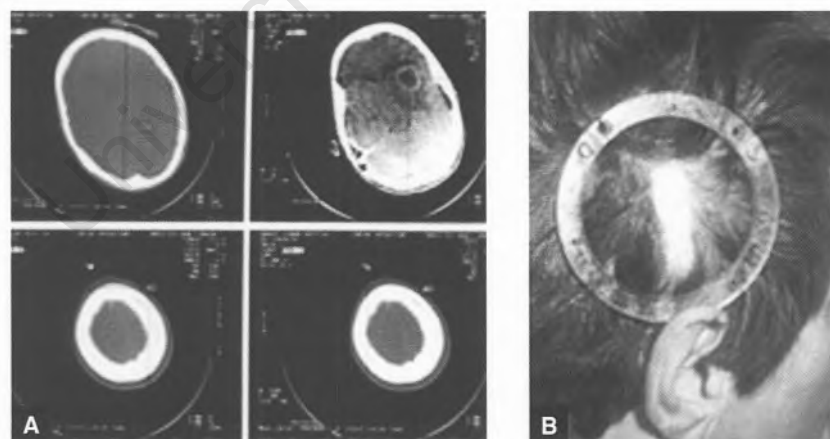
Scalp-mounted halo, attached with sutures. CT scan showing the target and the 3 fiducials clearly seen within the halo (a) and a different patient with the halo sutured in place and a small patch of hair shaved for surgery (b).
